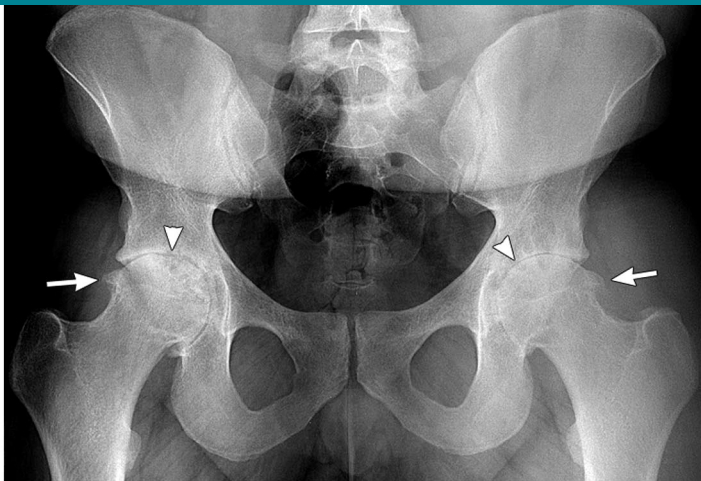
Rheumatoid arthritis with secondary osteoarthritis. Anteroposterior pelvis radiograph shows joint space narrowing of each hip joint. Note small erosions (arrowheads) and osteophytes (arrows). Sacroiliac joint involvement is also present with narrowing, irregularity, and sclerosis.
